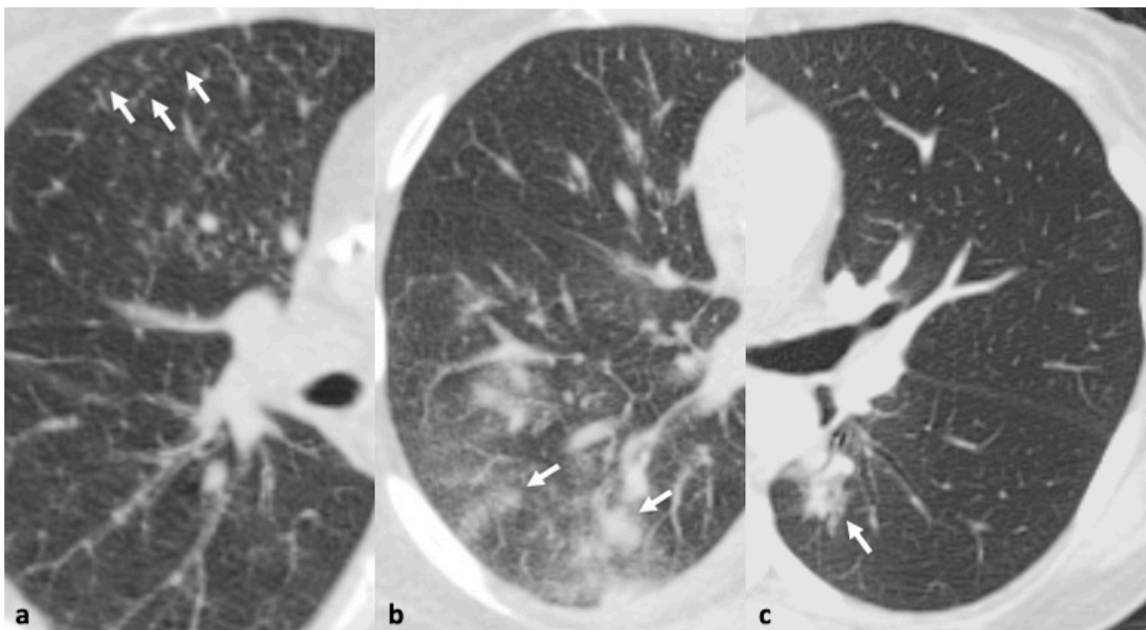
51-year-old woman with confirmed respiratory syncytial virus infection. 4a-c. Transverse thin section CT scan through the mid and lower zones demonstrates a few tiny nodules (arrows, a) and bilateral patchy areas of nodular ground glass opacity and consolidation (arrows b, c).
